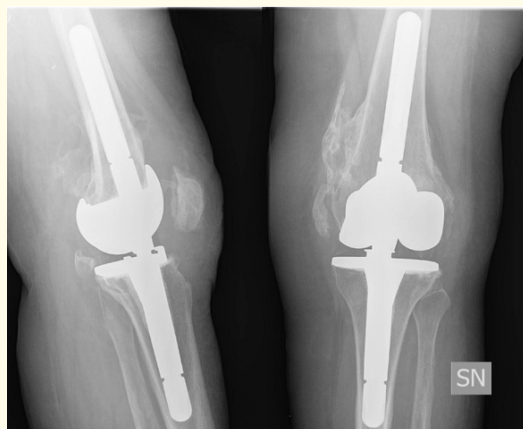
1-year x-ray follow up.
